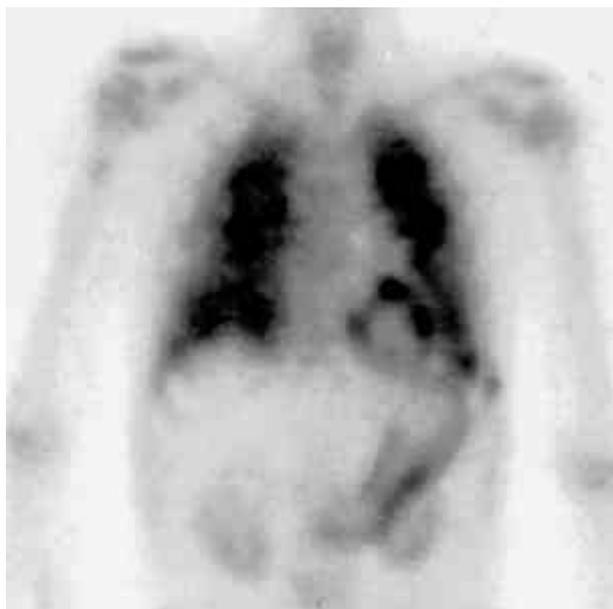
Tc-99m MDP bone scintigraphy of a 57-year-old man with hypercalcemia in the accelerated phase of chronic myelogenous leukemia shows diffusely increased uptake in both lung, heart, stomach and both kidneys.
